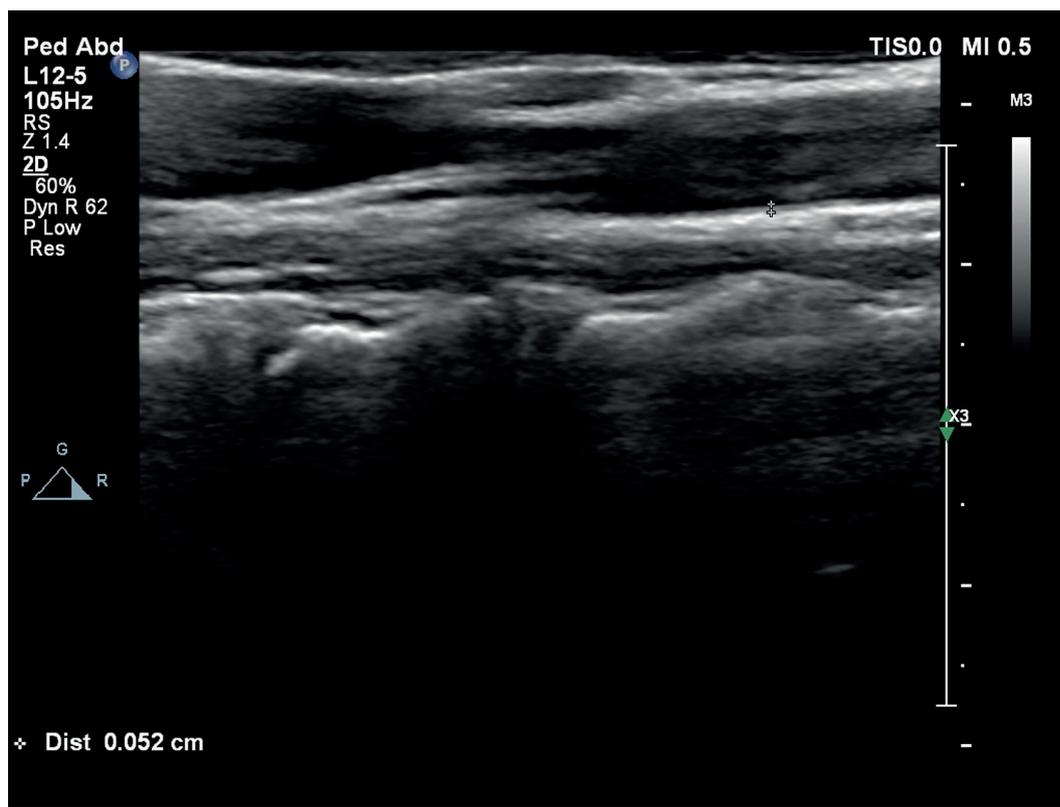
Common carotid intima-media thickness (CC-IMT) measurement by B-mode ultrasound in a patient with beta thalassemia minor (normal CC-IMT: 0.57 mm).
